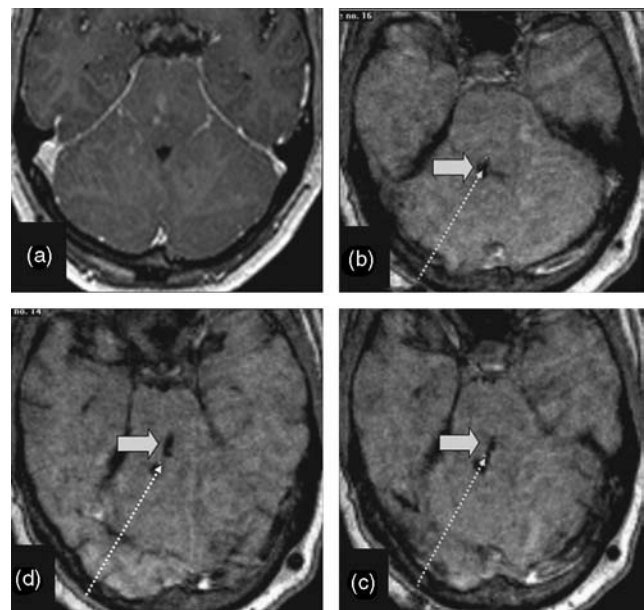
(A) Preoperative MRI scan showing a lesion in the brainstem, anterior to the fourth ventricle (B, C, and D). The pre- and postoperative images were fused. The site of the biopsy (arrow) and the planned trajectory of the needle (dotted arrow) can be noticed.
